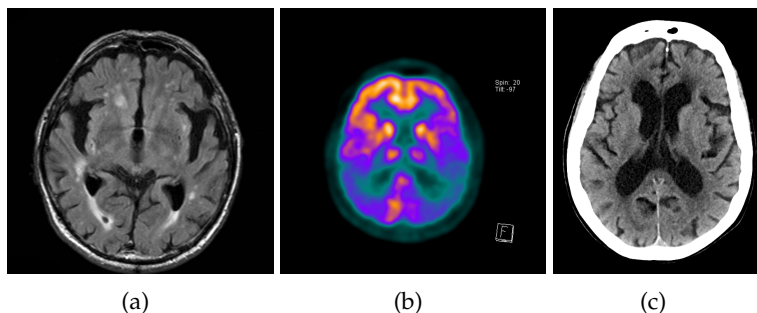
Some of the typical radiographic features of Alzheimer’s disease observed in three different patients on multimodal data: (a) cerebral volume loss on FLAIR, T2w hyperintense regions suggest a concurrent component of chronic small vessel ischaemic change (image and description source: case courtesy of Frank Gaillard, radiopaedia.org, rID: 10738), (b) decreased metabolism activity on the bilateral parietotemporal cortex (image and description source: case courtesy of Bruno Di Muzio, radiopaedia.org, rID: 22715), (c) volume loss and large ventricles on CT (image and description source: case courtesy of Frank Gaillard, radiopaedia.org, rID: 33753)
